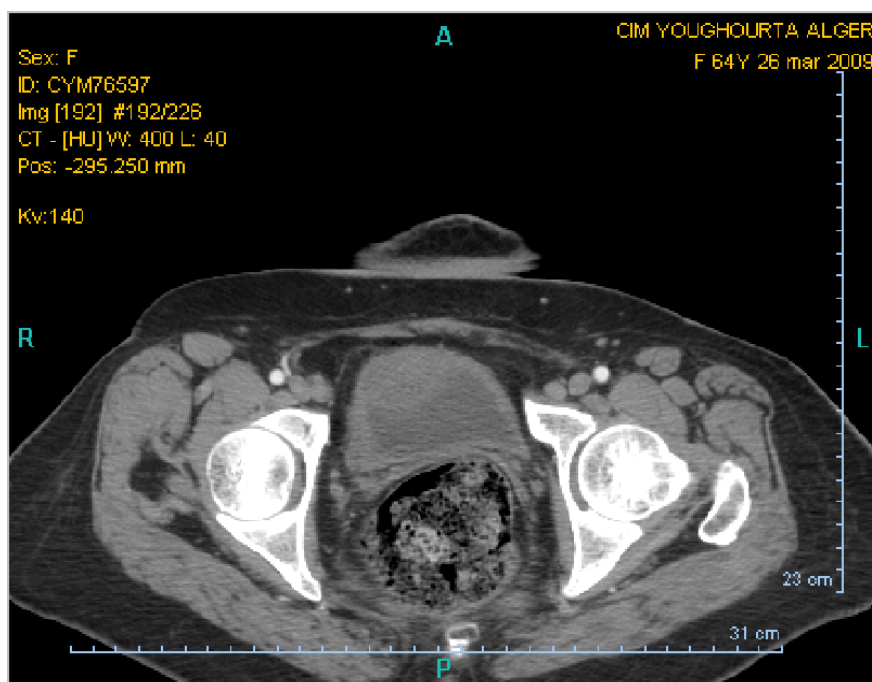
CT SCAN: Pelvic computed tomography. Absence of lesions at 2 months postoperative (Case 2).
